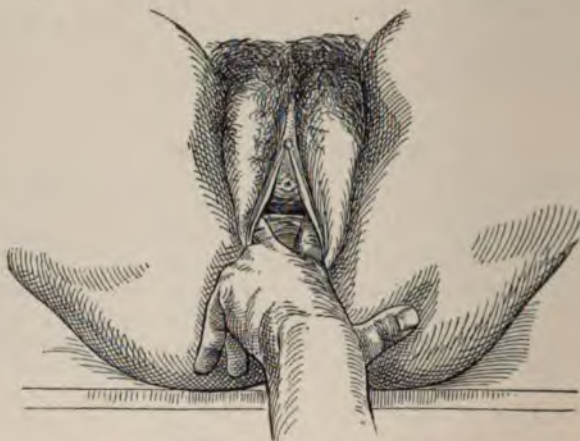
DIRECT INSPECTION OF THE VAGINA.
